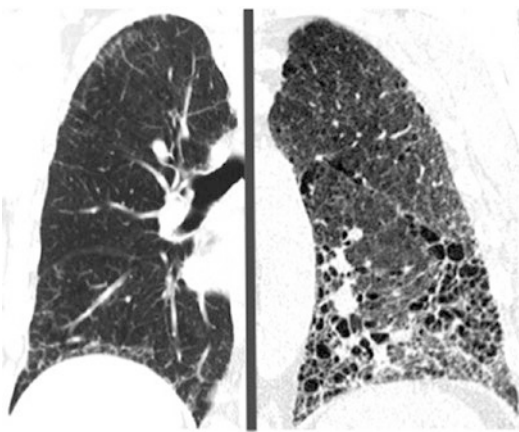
Comparison of CT features between NSIP and UIP. NSIP (left) shows diffuse lung involvement with bilateral, peripherally located linear and reticular opacities. In UIP (right) the lung abnormalities show a typical apico-basal gradient with predominance of honeycombing
